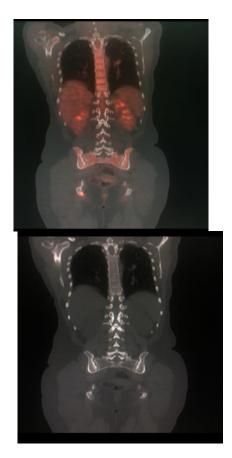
¹⁸F-FDG PET/CT shows FDG uptake at the right ischial bone agreeing with osteolytic lesion in CT cuts; positive for metastatic osseous deposits.
